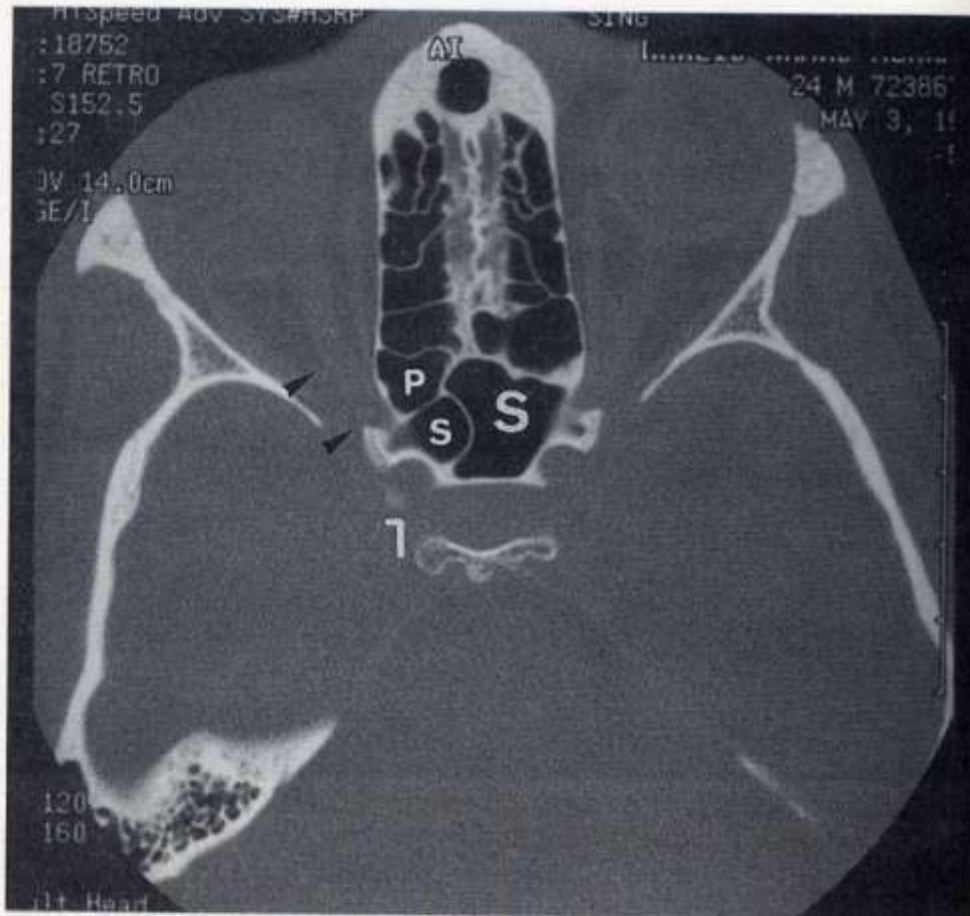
Axial CT shows the posterior relations of the right posterior ethmoid cell (P), right sphenoid sinus (s), left sphenoid sinus (S) and right optic nerve (arrowheads).
